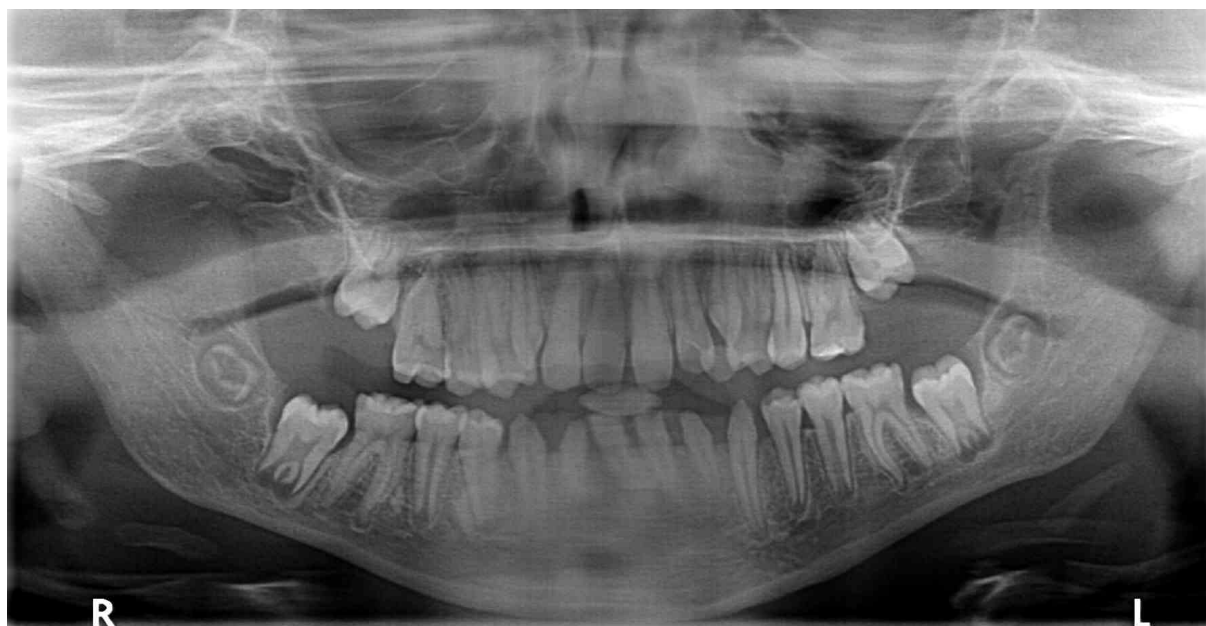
Panoramic radiograph of a 12-year-old girl treated for a malignant eye tumour with chemotherapy from 5 weeks of age to 6 months of age. Visible V-shaped roots of teeth 16 and 26, reduced conical crowns of teeth 32 and 42 and root shortening of the lower incisors.
